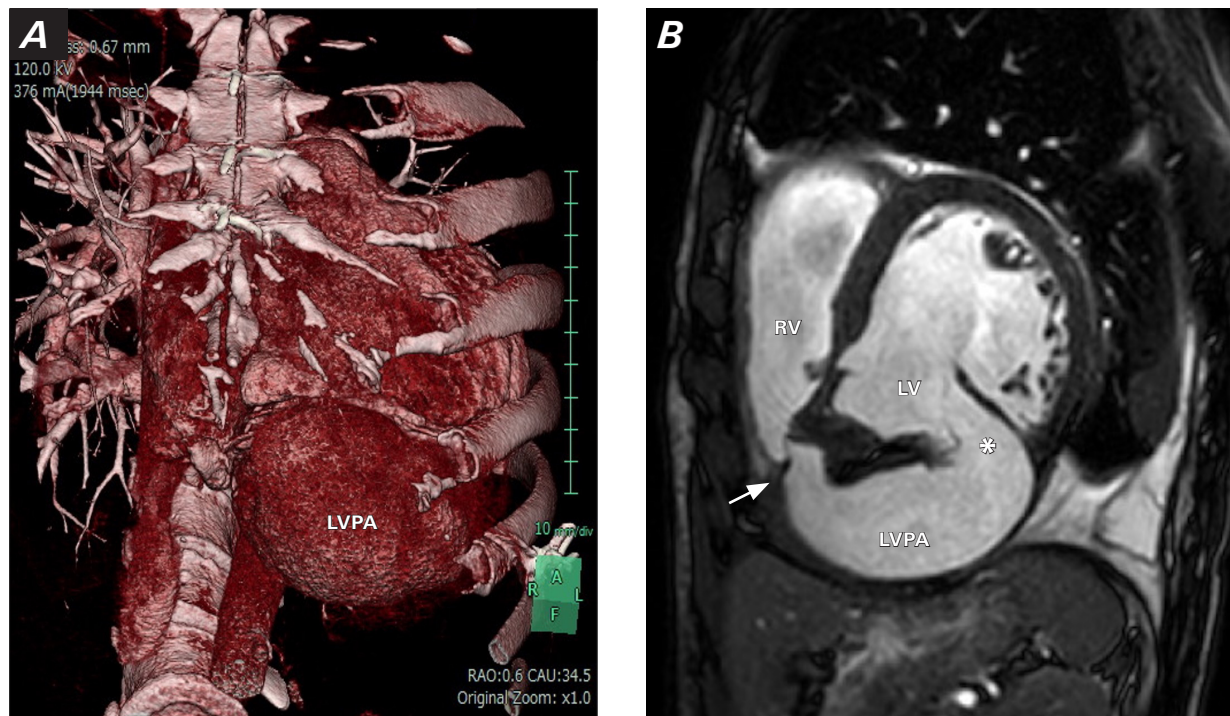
A) Three-dimensional volume rendering computed tomogram m shows a giant LVPA; B) magnetic resonance image, sagittal section, shows the orifice to the LVPA (asterisk) and a shunt hole to the RV (arrow).
